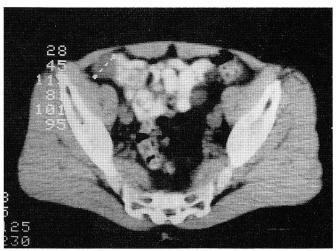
A CT scan of an undescended right testis.
